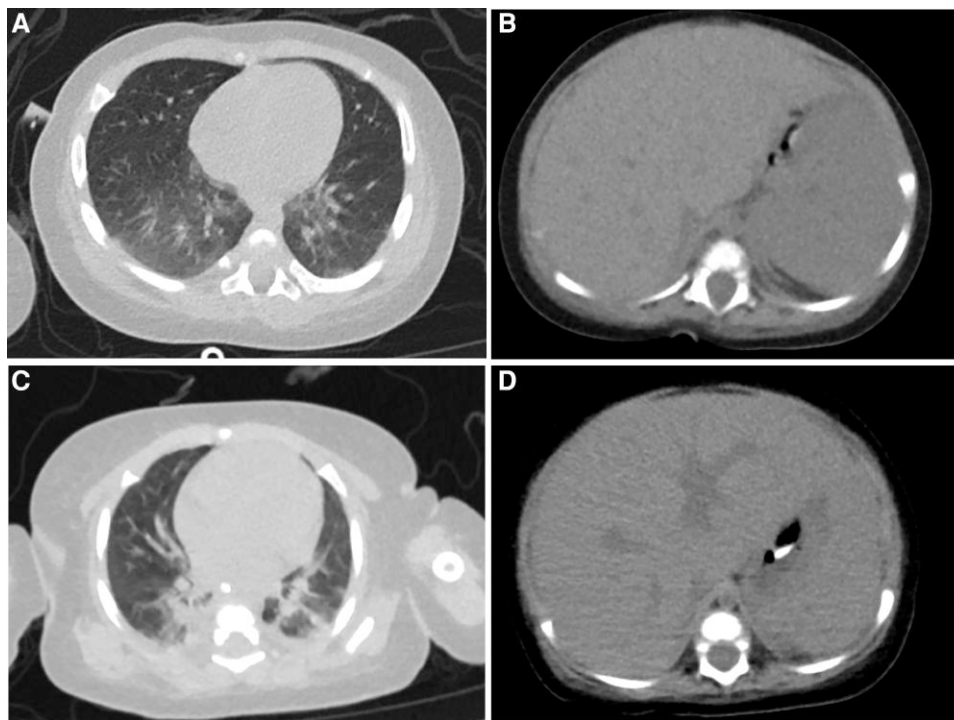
CT images of the thorax and abdomen for patient 1 and patient 2. *A*, CT image of the thorax for patient 1. *B*, CT image of the abdomen for patient 1. *C*, CT image of the thorax for patient 2. *D*, CT image of the abdomen for patient 2. Abbreviation: CT, computed tomography.
